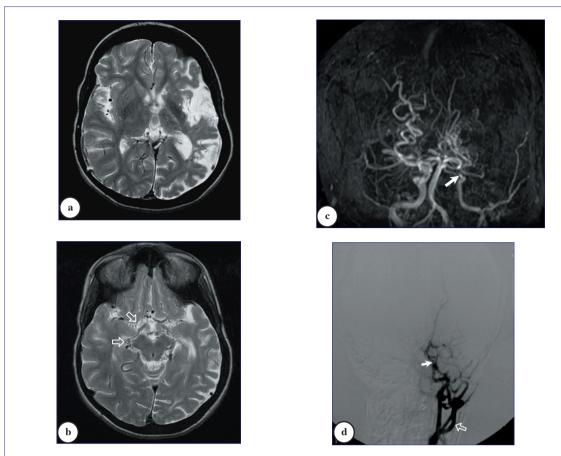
a) Axial T2-weighted image (T2WI) of the brain showing left temporal and left parietal cortical high signal intensity due to infarction. b) Axial T2WI depicting multiple signal voids in the basal cisterns (open arrows) due to dilated collaterals. c) MR angiography showing attenuated caliber of the left internal carotid artery more distally (arrow) with marked narrowing of the origin of left anterior and middle cerebral arteries. Attenuated caliber of the left posterior cerebral artery with multiple dilated collaterals is also shown. d) Digital subtraction cerebral angiogram showing the markedly attenuated caliber of the left internal carotid artery more distally (arrow) with non-visualization of the anterior and middle cerebral arteries. Open arrow points to the external carotid artery.
